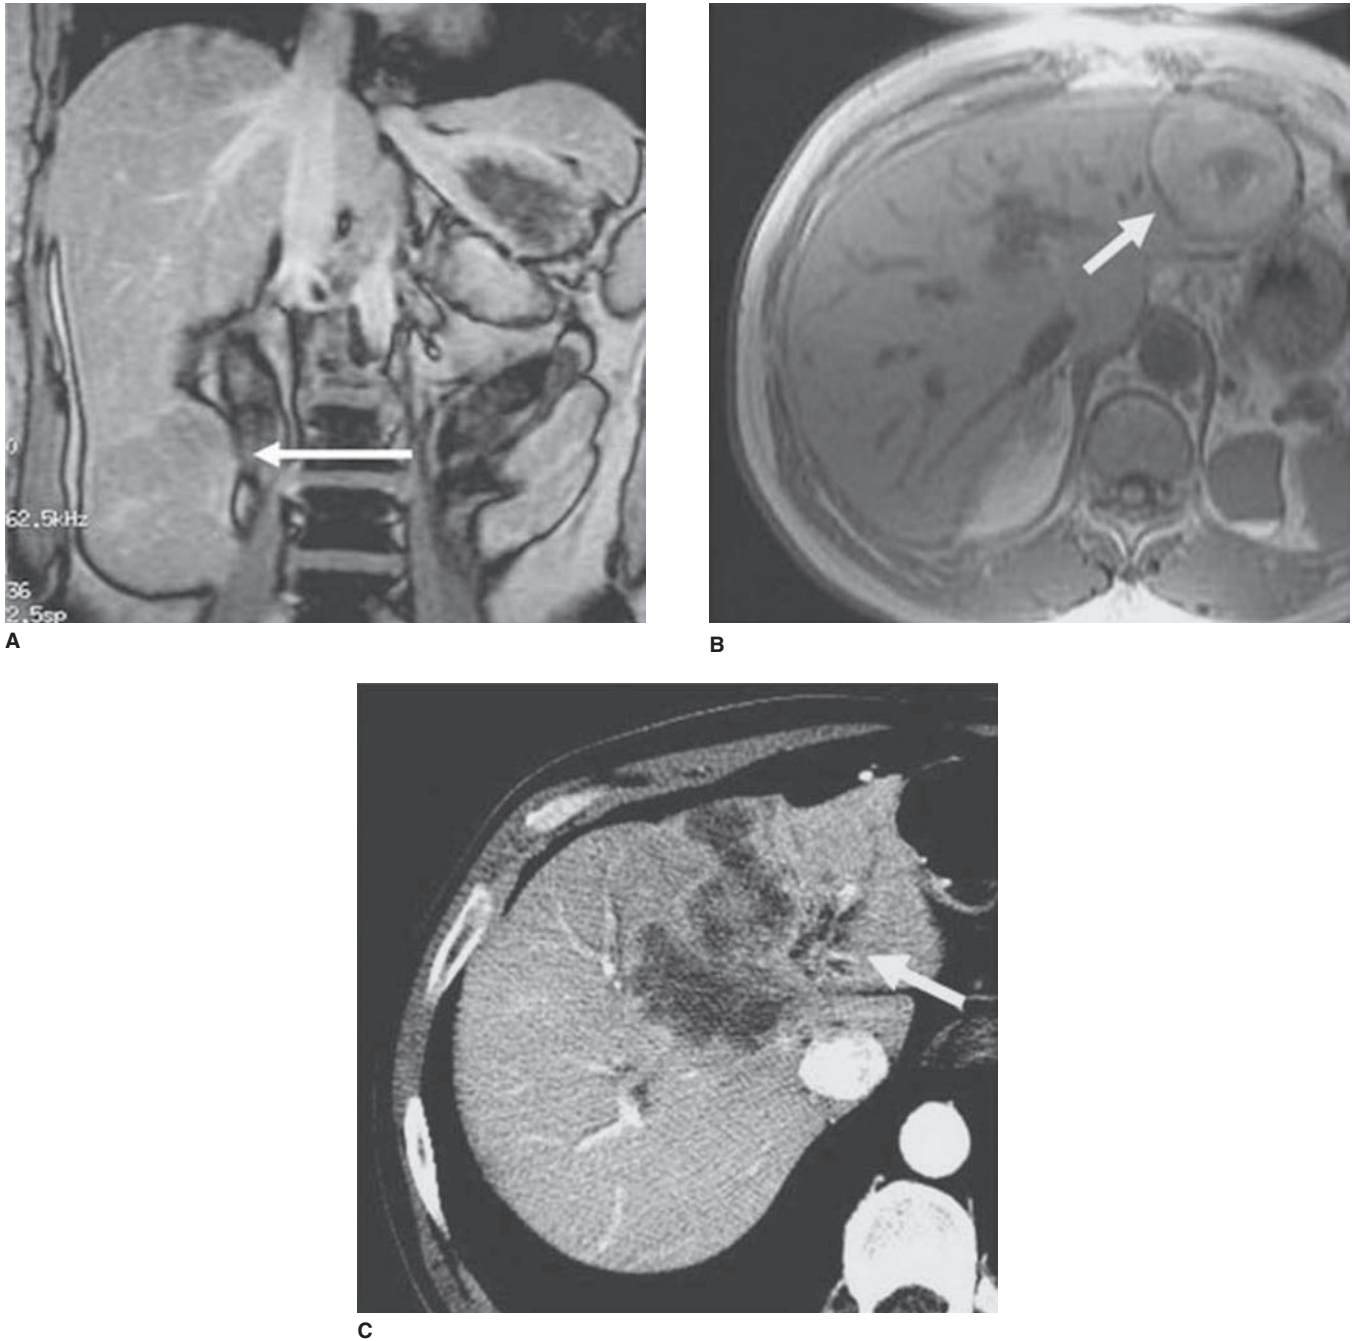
Growth patterns of hepatocellular carcinoma. A. “Hanging” type. MRI demonstrating a mass (*arrow*) that is attached by a stalk to the right lobe of the liver. B. “Pushing” type. These are generally encapsulated, well-circumscribed tumors (*arrow*). C. “Infiltrating/invading” type. This lesion has diffusely infiltrated the entire left two-thirds of the liver. Note the left biliary ductal dilation (*arrow*).
